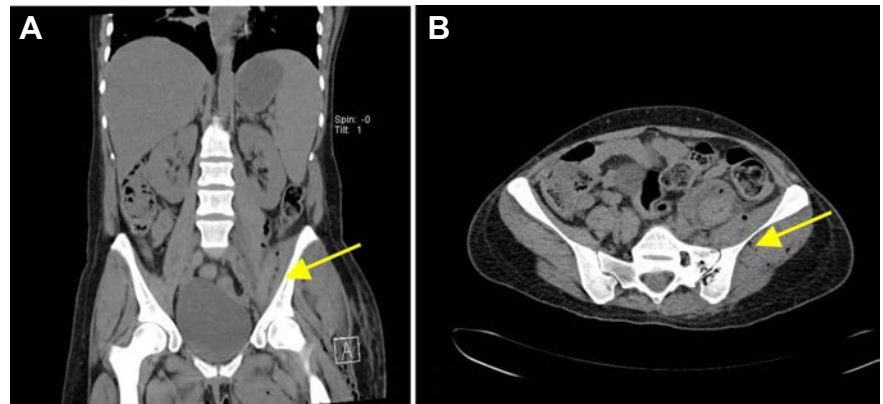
Abscess of the M. psoas on the left side up to lumbar vertebrae two: MRI T1, frontal (A) and MRI, T1, coronar (B).
